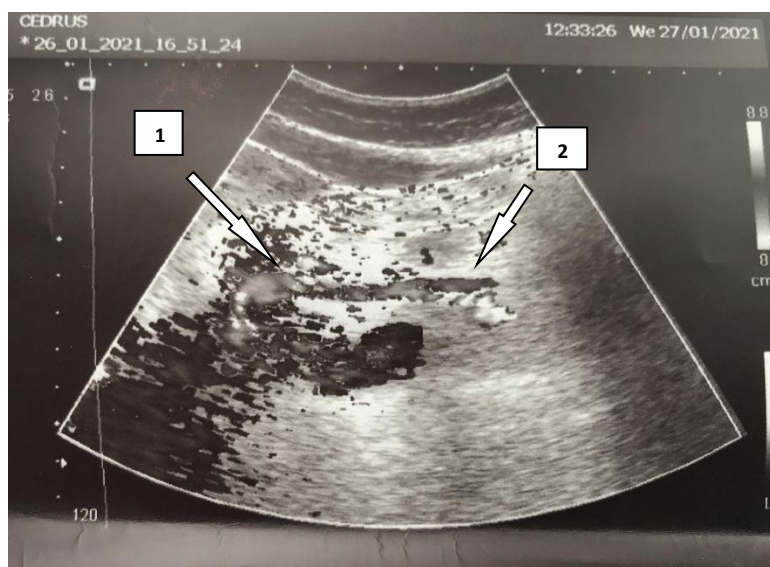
Ultrasonography of visceral arteries: 1 – Superior mesenteric artery aneurysm; 2 – Superior mesenteric artery.
